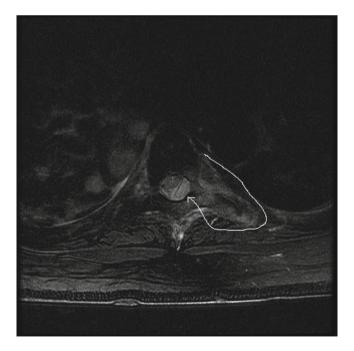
MRI scan of the thoracic spine. At the T6 level, the epidural tumor (*outlined*) is causing impending compression of the spinal cord (*arrow*)
